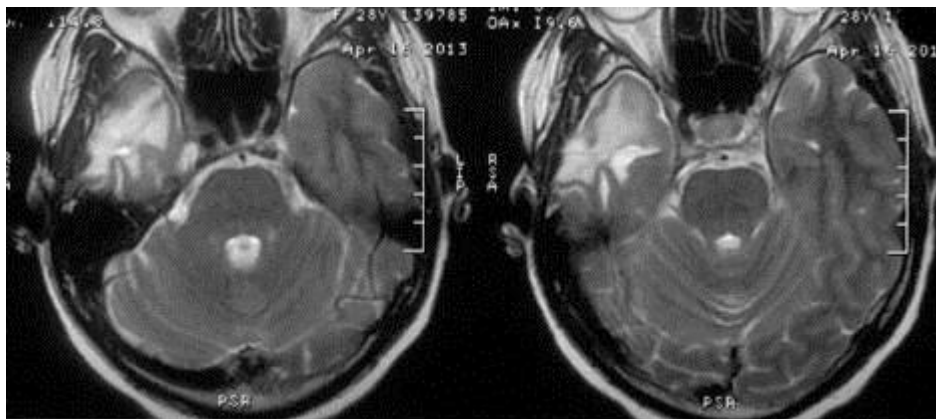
Axial T2 weighted brain MRI. Enhanced area of encephalomalacia and gliosis at right temporal is due to post treatment changes, without obvious signs of recurrence.
